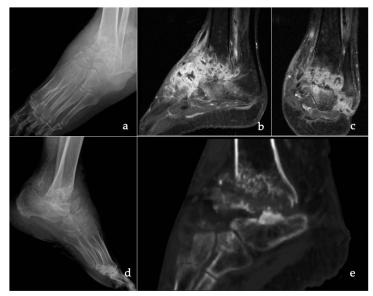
A) pre-operative anteroposterior X-ray of foot and ankle; B) sagittal view; and C) coronal view of pre-operative left foot and ankle MRI; D) pre-operative X-ray lateral view; E) sagittal view of pre-operative CT-scan (Fondazione Policlinico Universitario Agostino Gemelli IRCCS, 2022)
